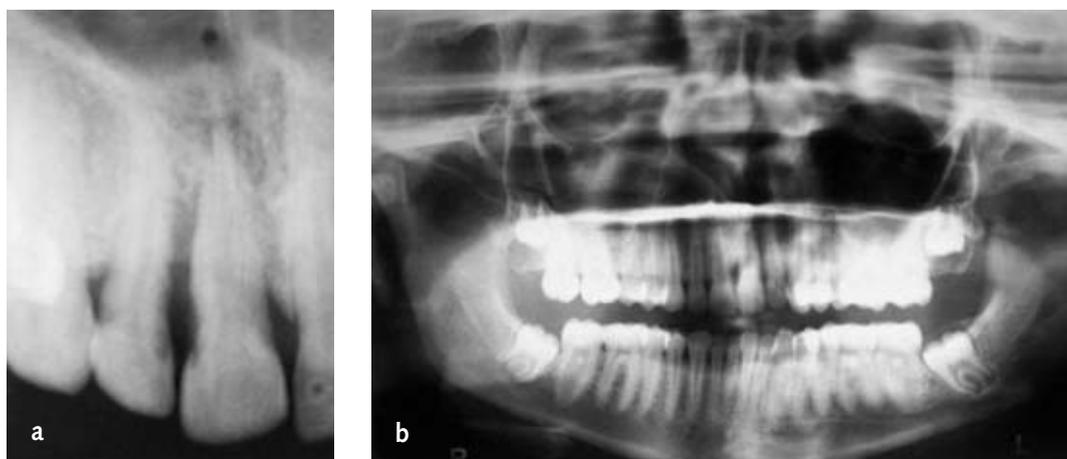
Radiographs showing marked localised bone loss.
